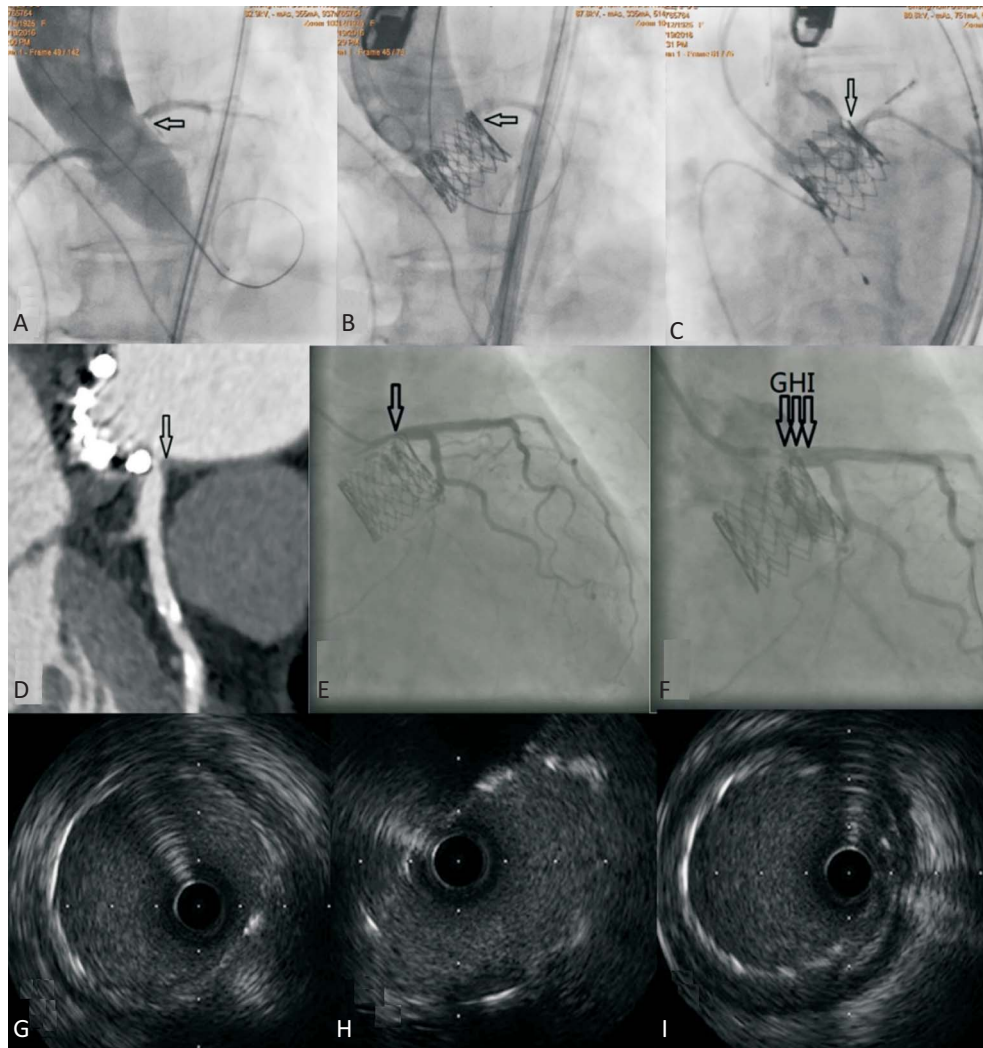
A 90-year-old woman was admitted with symptomatic, severe aortic stenosis for transcatheter aortic valve replacement (TAVR). Pre-implantation computed tomography indicated left and right coronary ostial heights of 13.4 mm and 17.6 mm, respectively. During balloon valvuloplasty for pre-dilatation with a 25 mm × 40 mm balloon, the left aortic leaflet was displaced toward the left coronary ostium (A, arrow); therefore, we decided to perform coronary protection. A 29 mm SAPIEN XT valve (Edwards Lifesciences) was then implanted. Aortography suggested the presence of stent frames of TAVR device close to, but not obstructing, the left coronary ostium (B, arrow). A post-TAVR selective angiography also showed a patent left main stem (LMS) with TIMI 3 flow (C, arrow). The patient was discharged uneventfully but a computed tomography follow-up six month after TAVR showed new tissue growth near the ostium of LMS (D, arrow). The patient declined percutaneous coronary intervention at that time because she continued to do well. Another 5 months passed, the patient was admitted for unstable angina and the LMS was stented with a 4.0 mm × 12 mm integrity resolute stent (Medtronic) (E, arrow). Post-dilatation with a 4.5 mm non-compliant balloon led to improvement in the angiographic appearance of the stent (F, arrows). Intravascular ultrasound examination demonstrated improvement in minimum lumen area and diameter, but residual ovoid-shaped stented segment discovered at the site of the impingement of stent frames of the TAVR device (G-I).
